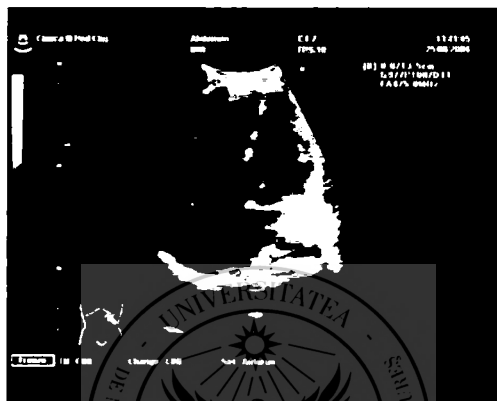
Echocardiographic image: double outlet RV, after palliative surgical correction
